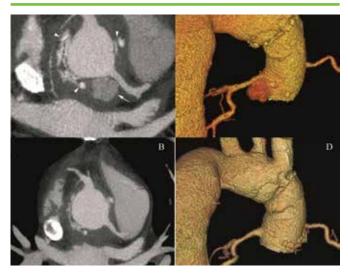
Thoracic CT Scan images (transverse sections) before (A) and after (B) the spontaneous closure of the pseudoaneurysm (arrows). 3D Volume Rendering CT scan reconstructions before (C) and after (D) the spontaneous closure of the pseudoaneurysm (arrows). Surgical pledgets (arrowheads).
